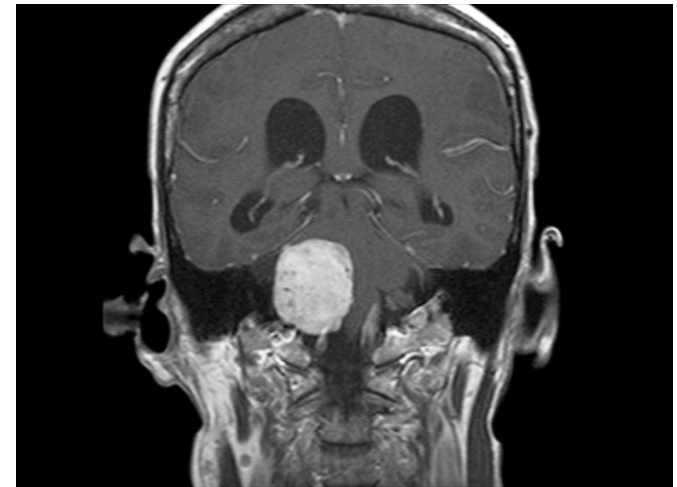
Giant vestibular schwannoma. Coronal Gd-enhanced T1 MRI sequence shows a giant right vestibular schwannoma measuring 4.1 cm in the anteroposterior and 3.5 cm in the craniocaudal dimension. Note the resulting hydrocephalus from brain stem and fourth ventricle compression.
